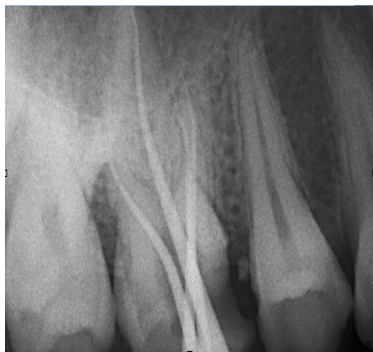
Master cone radiograph showing two mesiobuccal canals
